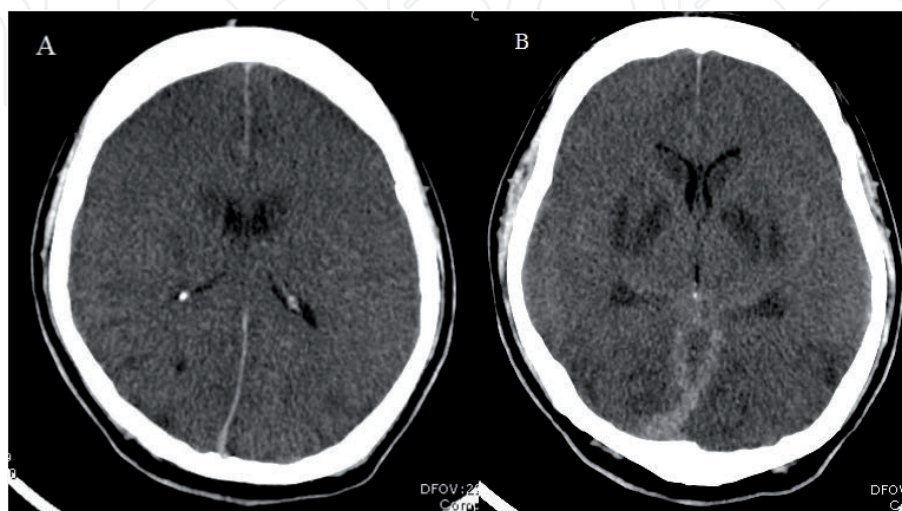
CT-Brain in a patient with severe hypoxic/ischemic brain injury: diffuse cerebral edema with effacement of the gyri and sulci (A), loss of cortical gray-white differentiation, bilateral hypodensities involving the deep gray nuclei (B).
